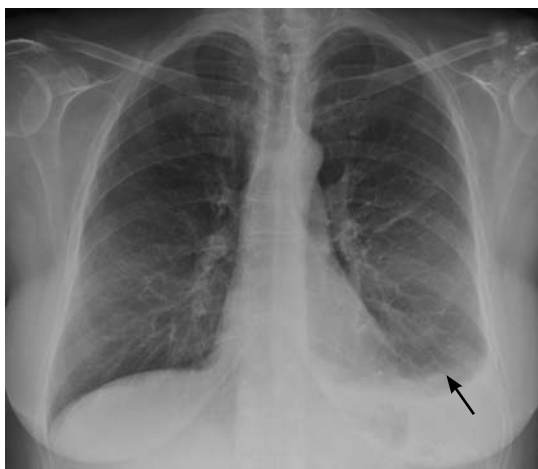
Radiography (top) and computed tomography (bottom) revealed a unilateral pleural effusion (arrows).
